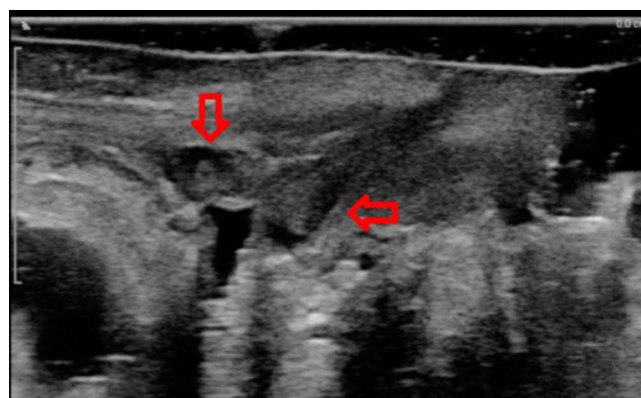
Postoperative transvaginal midsagittal sonographic view of the urethra, using an endocavitary linear probe. Ultrasound evaluation demonstrated the presence of bulking agent locations (arrows) in the proximal urethra.
